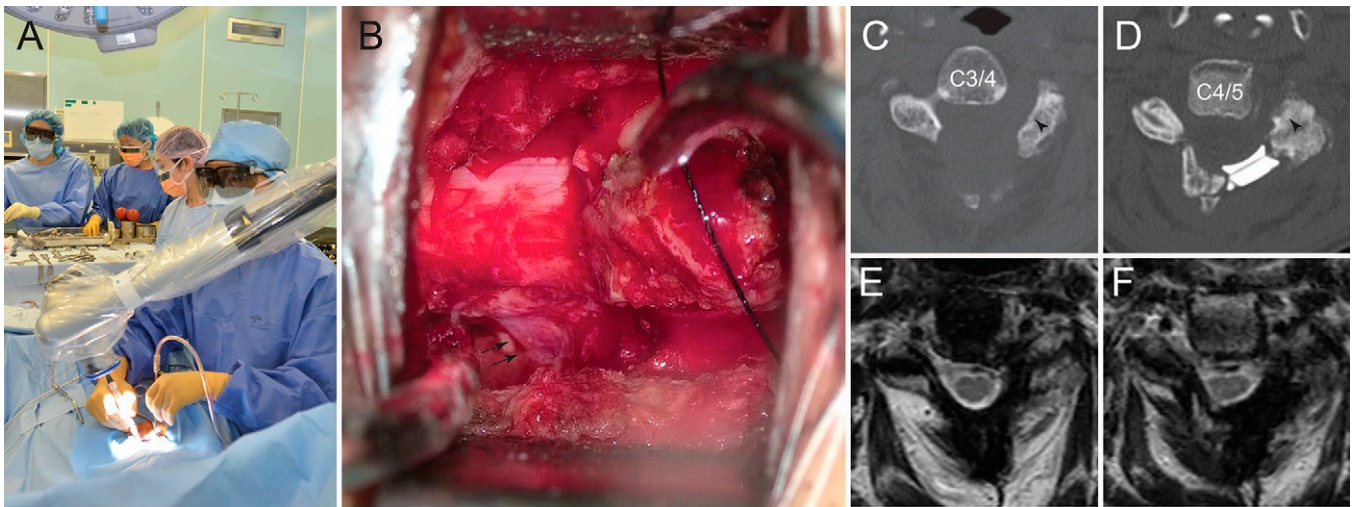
Overview of foraminotomy using an exoscope in look-up surgery (A). After a foraminotomy, the C4 nerve root is exposed in an intraoperative view (B). Postoperative CT demonstrating C3 laminectomy (C), C4 laminoplasty (D), and foraminotomy (arrowheads). MRI reveals decompression of the spinal nerve roots and spinal cord at the C3 (E) and C4 (F) levels.
